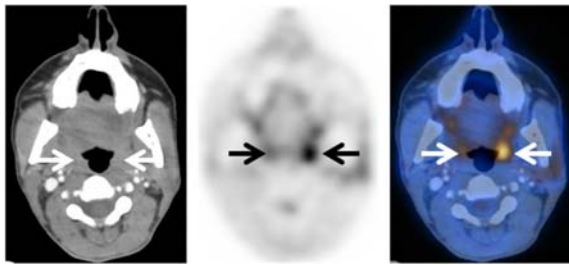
Post treatment changes in the right tonsil in a 33-year-old female with a history of right submandibular gland cancer status post resection follow by radiation therapy for 5 months. Axial images of a PET/CT study shows asymmetrical FDG uptake in the tonsils (arrow), left more than right, without any appreciable mass on the accompanying CT scan. Given the patient has a history of prior radiation therapy to the right neck, these findings were interpreted as post treatment change in the right tonsil and subman-dibular gland
